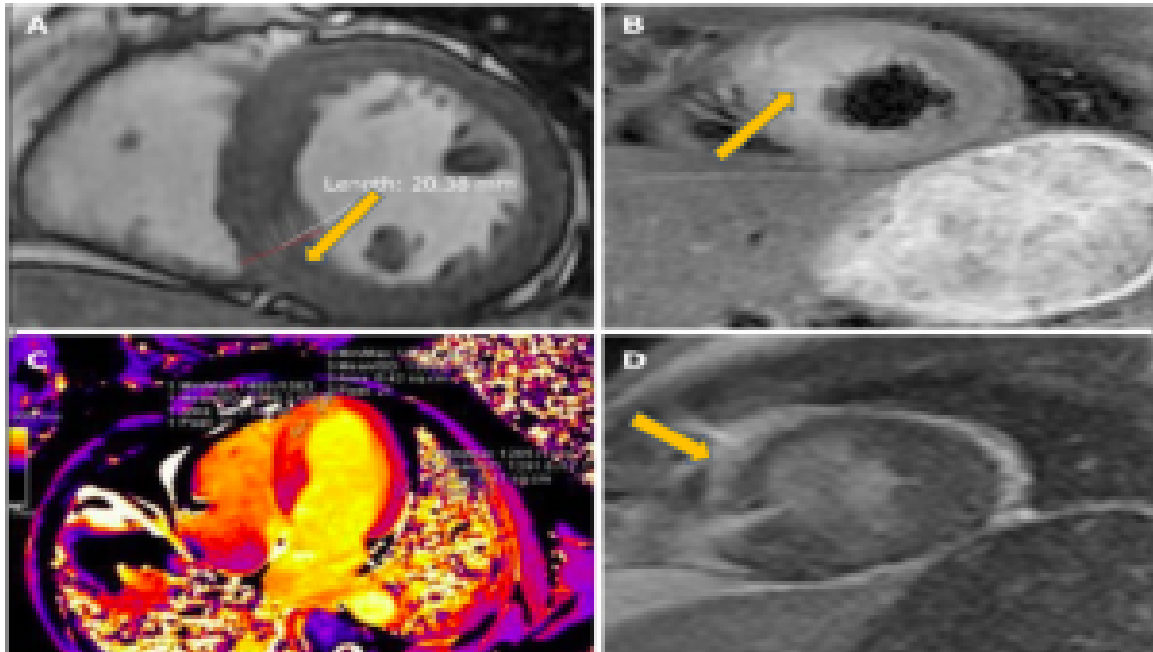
Cardiovascular magnetic resonance imaging. A: In the [pb_glossary id="526"]CINE[/pb_glossary] sequence at the left ventricular end-diastolic phase, the ventricular wall (yellow arrow) was 20.38 mm (normal 12 mm). B: FS-T2WI showed obvious edema (yellow arrow); C: The T1 mapping showed that the T1 value of the walls was obviously higher than that of the normal walls (1586.3 ms vs 1291.6 ms) in the interventricular septum in the first cardiovascular magnetic resonance. D: Late gadolinium enhancement (yellow arrow) of the endocardium and middle myocardium of the middle and apical septal walls.¹
